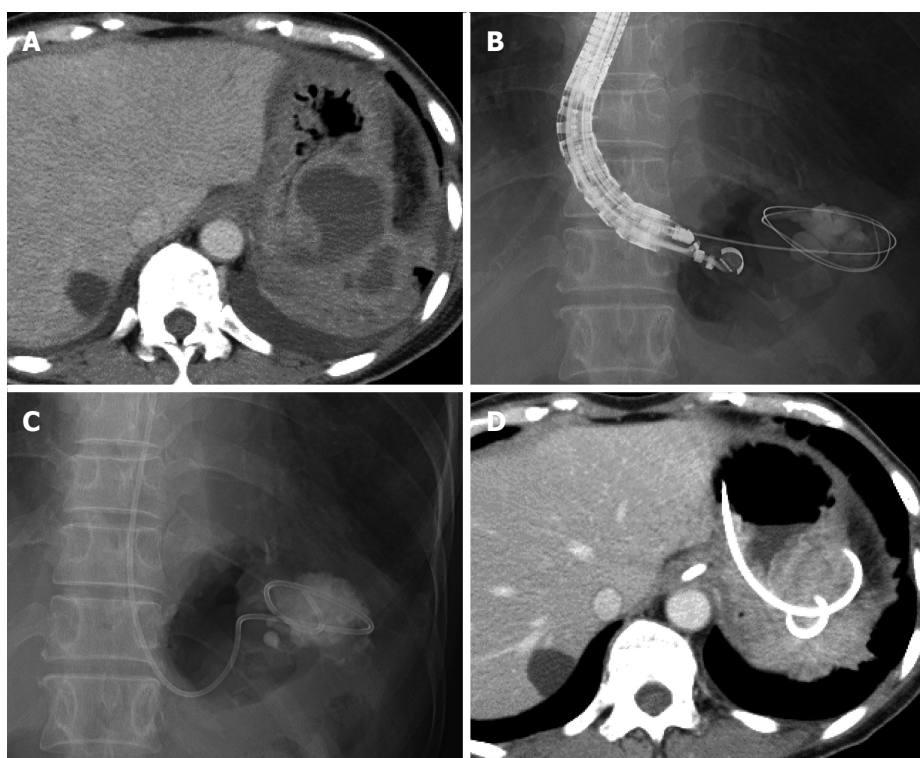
Case 1. A: Computed tomography (CT) reveals an encapsulated fluid collection in the left subdiaphragmatic area close to the fornix of the stomach; B and C: Fluoroscopy image showing the guidewire inserted into the fluid collection under endoscopic ultrasound (EUS)-guidance and placement of a 6-Fr nasal biliary catheter; D: Six days after EUS-guided drainage, CT reveals that the drain was placed and that the fluid collection decreased.
